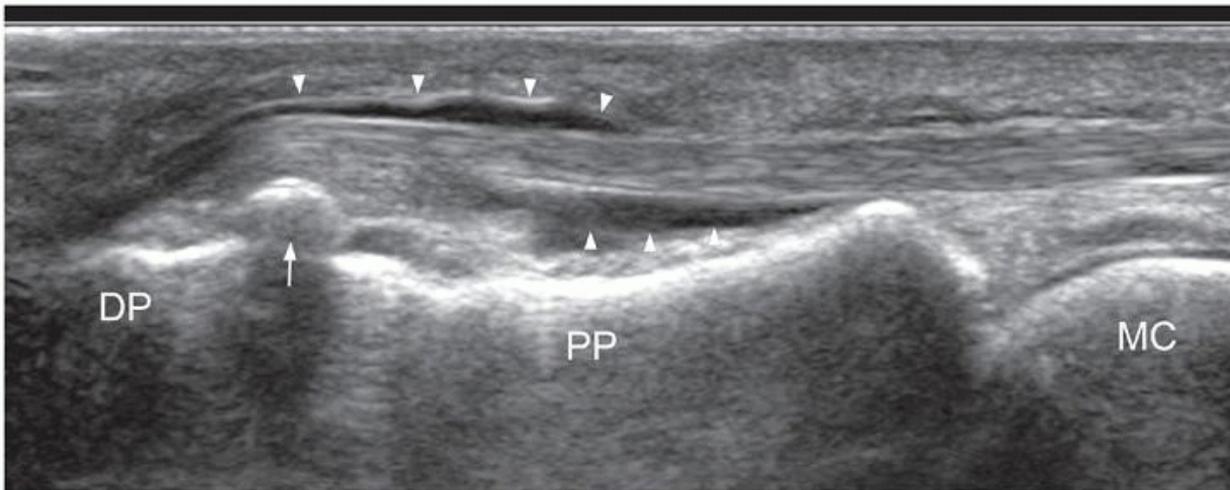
Longitudinal ultrasound of the big toe showing a moderate tenosynovitis (arrowheads) of the FHL tendon with a tendon sheath effusion surrounding a mildly swollen but otherwise normal tendon. Note the sesamoid bone (arrow) overlying the distal interphalangeal joint. MC, metatarsal; PP, proximal phalanx; DP, distal phalanx.
